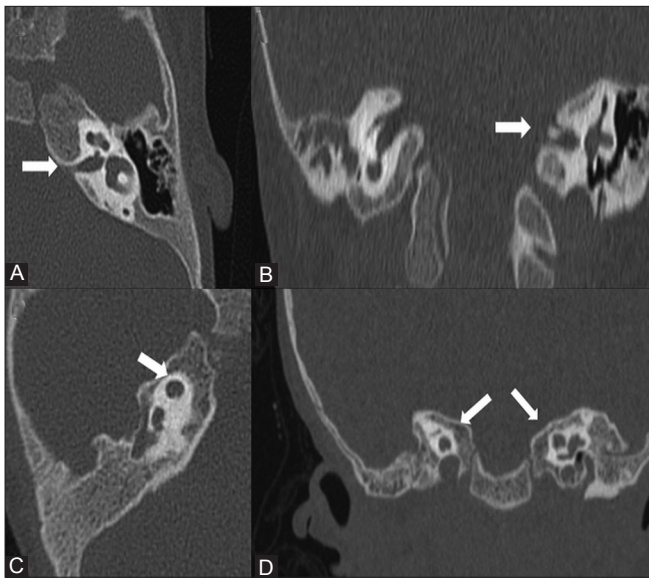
(A-D): Inner ear anomalies. (A) Axial HRCT section shows narrowed left internal acoustic meatus (arrow). (B) Coronal HRCT of same patient shows similar finding. Note normal right IAC. (C) Axial HRCT section shows globular cochlea (arrow) with dysplastic modiolus. (D) Coronal HRCT of same patient shows bilateralism of cochlear dysplasia (arrows)
